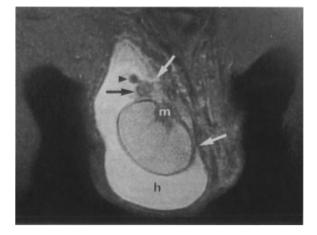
Torsion of the epididymal appendix is shown on a T2-weighted coronal scan obtained in a patient with acute scrotal pain. Note the "bare area" of the testis (distance between white arrows), made visible by the hydrocele (h) excluding testicular torsion. The torsed appendix is full of blood that appears dark on T2-weighting (arrowhead) (it was bright on a hydrogen density weighted image not shown here), and is attached to a normal epididymal head (black arrow). Also note the normal testis and its mediastinum (m). (BAKER et al. 1987b)
